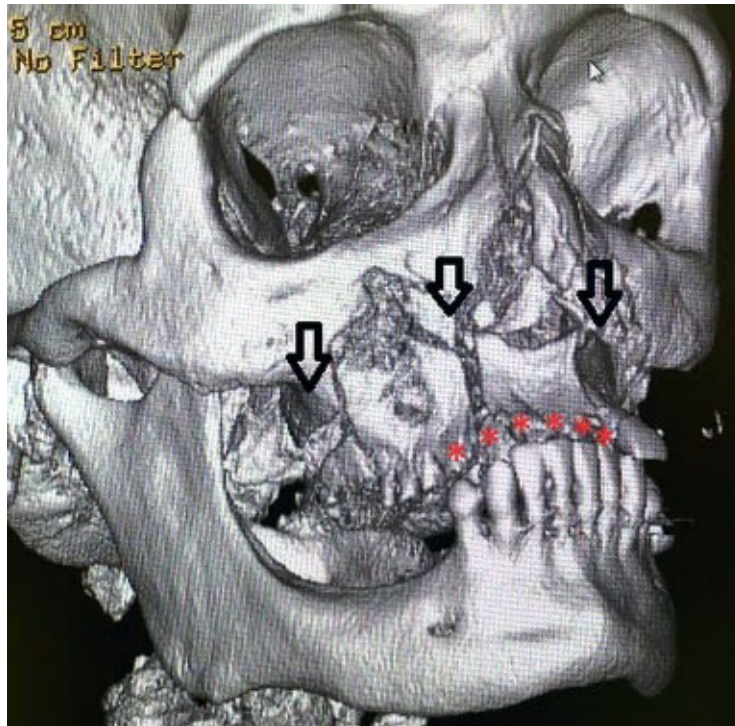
• CT scan showing Le Fort I maxillary fractures. Note the posterior impaction of the maxilla due to the trauma. Often segmental fractures (*arrows*) and loss of dentition (*asterisks*) are also seen.
